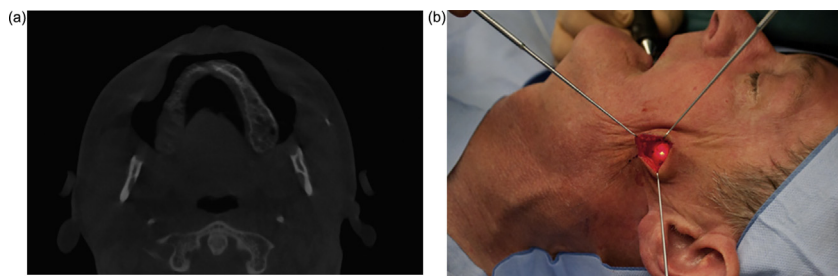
(A) CBCT scan (axial view) showing a parotid gland stone in the middle third of Stensen's duct. (B) The stone was visualized on the monitor with the sialendoscope. The skin was opened at the point where the light from the endoscope was seen. After blunt preparation towards the light, the duct was opened and the stone removed (the so-called 'combined approach').
